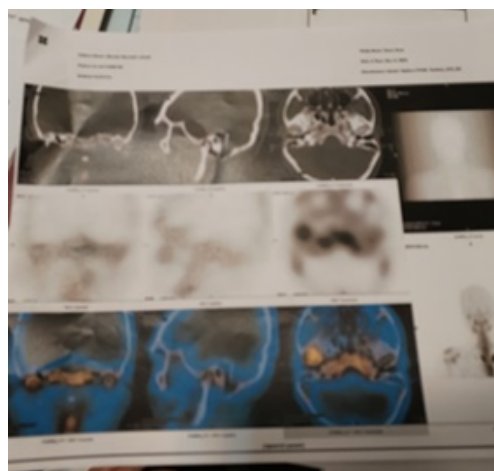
SPECT view of condylar activity.
